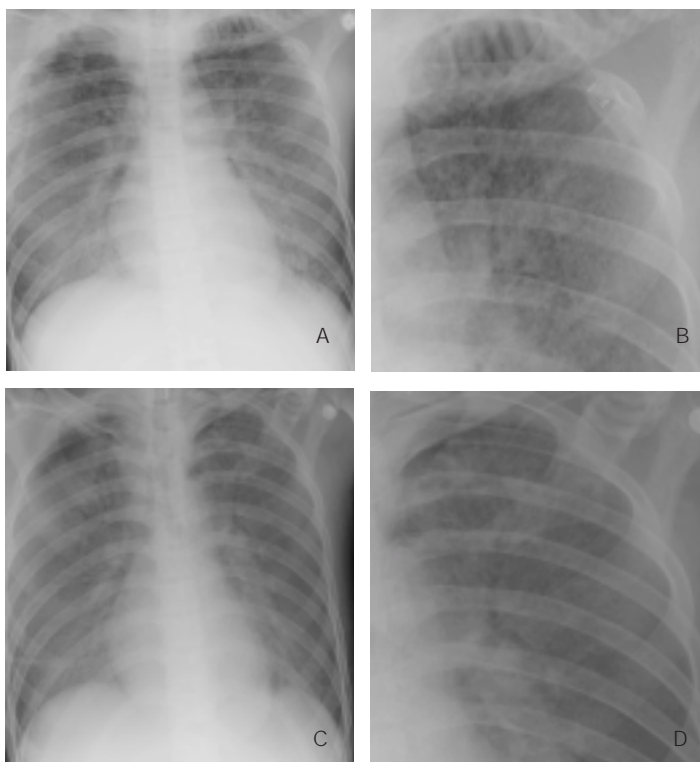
The most common abnormal chest radiographs found in our leptospirosis patients (A) showed multiple ill-defined nodules in both lungs (A, with a magnified view of a left upper lobe, B) that subsequently became confluent and turned to bilateral patchy infiltration (C, with a magnified view of the left upper lobe, D).
